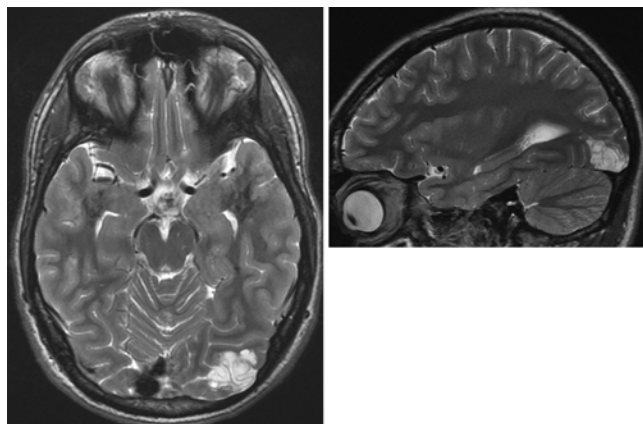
Case 11. Axial (left) and sagittal (right) T2-weighted MR images showing an incidental occipital mass lesion (assumed diagnosis of DNT) that was found in a 10.8-year-old boy after a traffic accident.
